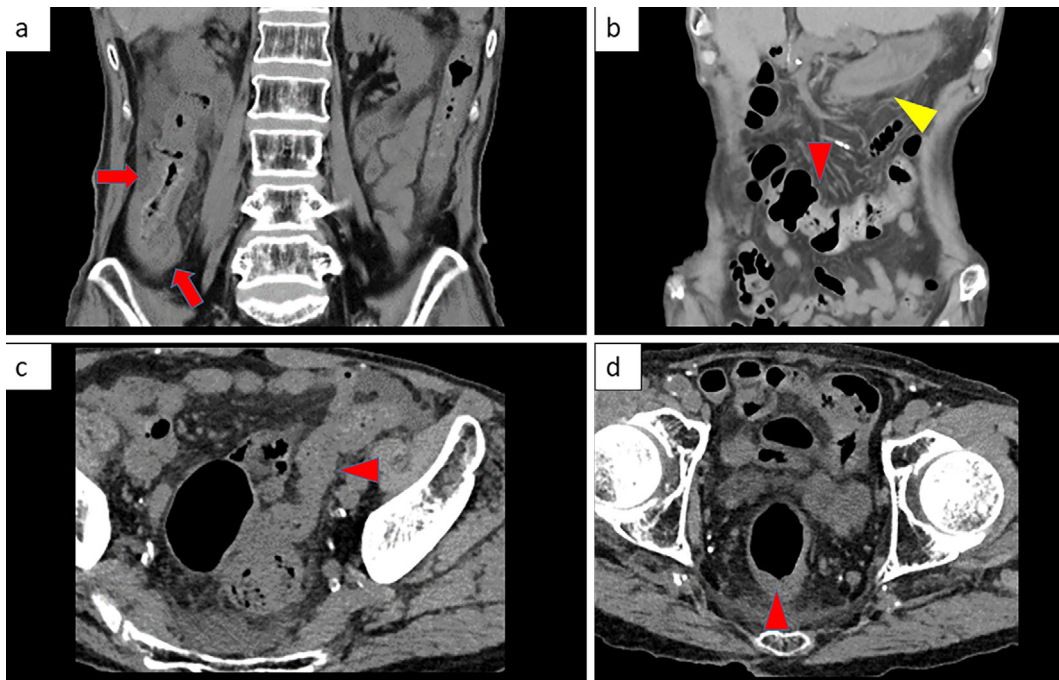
(a) Residual bowel wall thickening and slight fat stranding are observed around the ascending colon (arrow). (b-d) CT images showing significant improvement in the edematous mucosa between the transverse colon and the rectum (arrowhead). Gastric wall thickening partially remained (yellow arrowhead). CT: computed tomography
